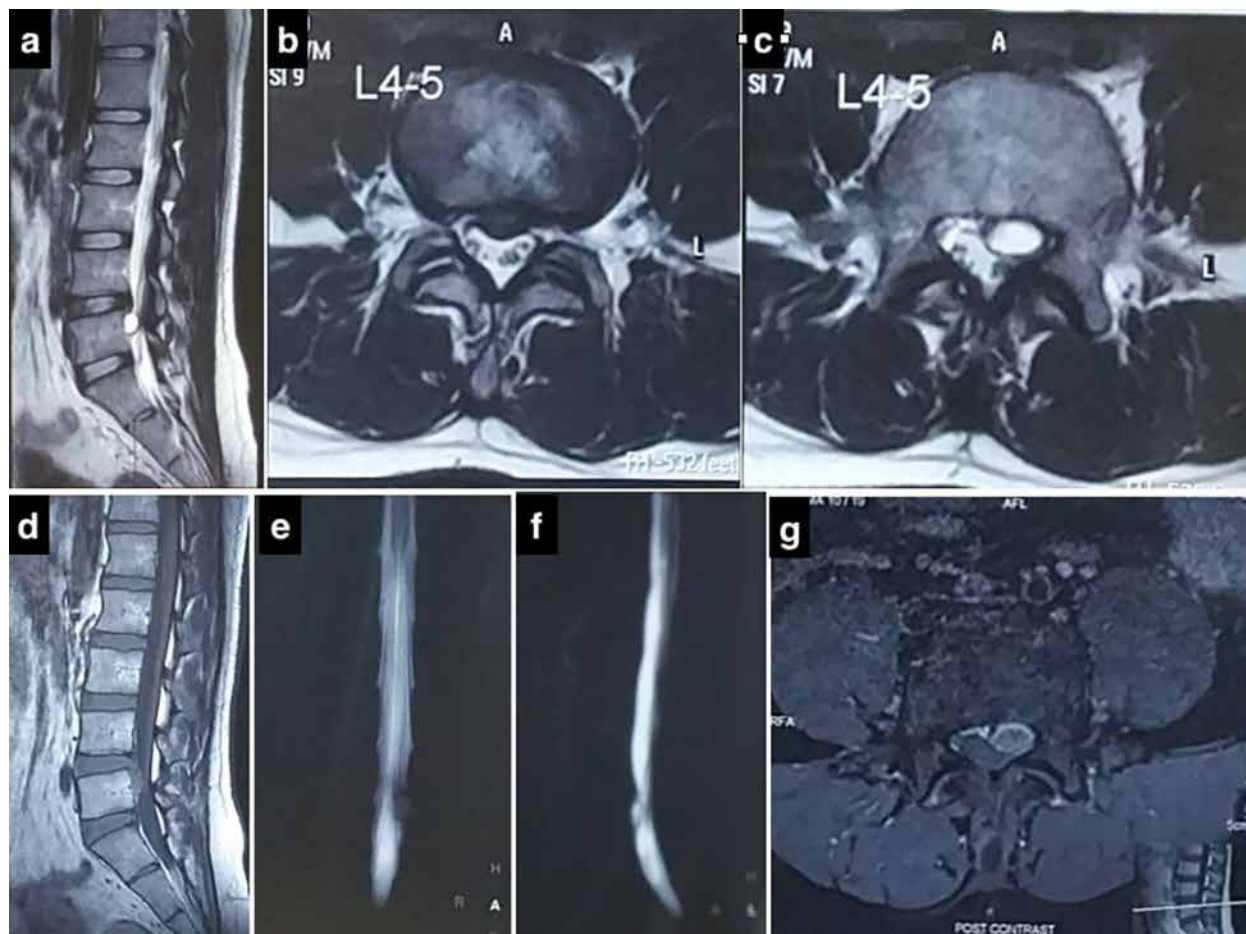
Preoperative MRI: (a,d) Parasagittal T2- and T1-weighted image showing 15X12X8.5-mm uniloculated discal cyst located in left paracentral down-migrated-like position. (b,c) Midsagittal T2-weighted axial image showing a central-to-paracentral disc in subligamentous location, with a left juxtapedicular paracentral location of cyst in axial section at pedicle level. (e,f) Magnetic resonance (MR) myelogram showing the cyst with contrast MRI axial image (g) showing rim enhancement.
